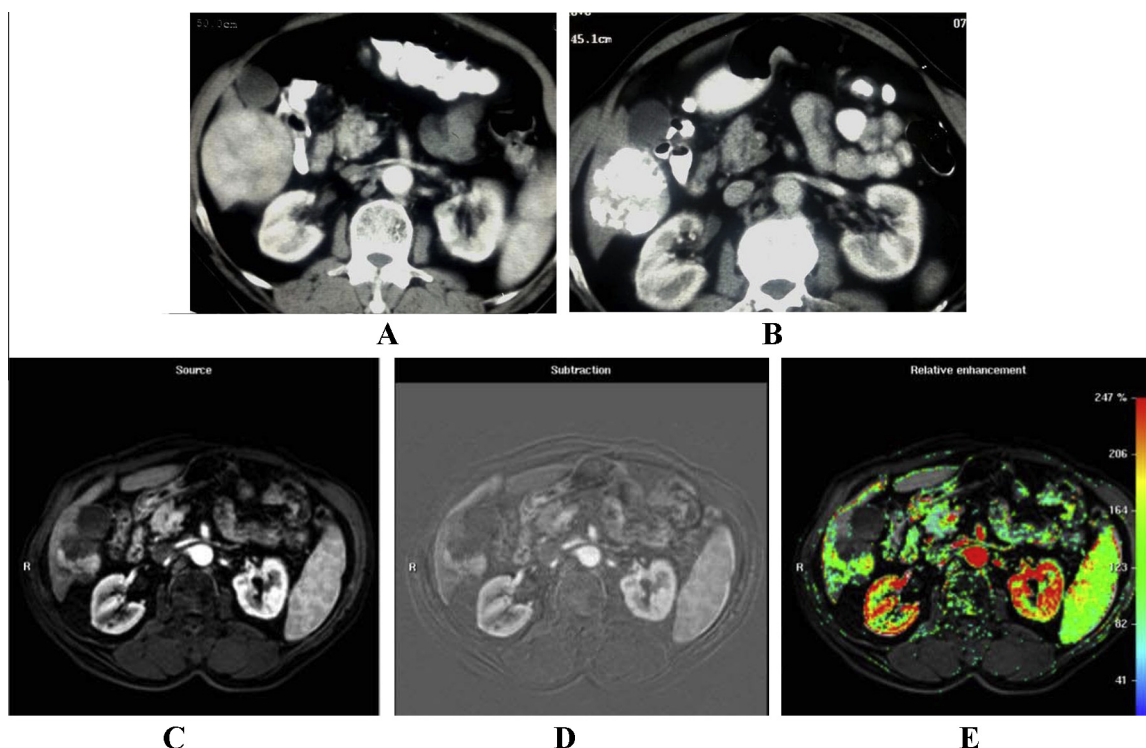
The effect of hardening artifact on the interpretation of CT findings. (A) arterial phase contrast enhanced CT of a 60 year old male showing a well defined right hepatic lobe (segment VI) heterogeneously enhancing mosaic HCC. (B) Post TACE arterial phase contrast enhanced CT of the same patient showing type II lipidol accumulation within the tumor; partial defect in the tumor; with difficulty to detect residual enhancing portions due to hardening artifact. (C–E) Dynamic MRI of the same patient (C) Early arterial phase of T1 THRIVE (High Resolution Isotropic Volume Examination), (D) Corresponding subtraction image and (E) Corresponding relative enhancement color mapping image. They show clearly the residual enhancing portions without being affected by the lipidol signal.
